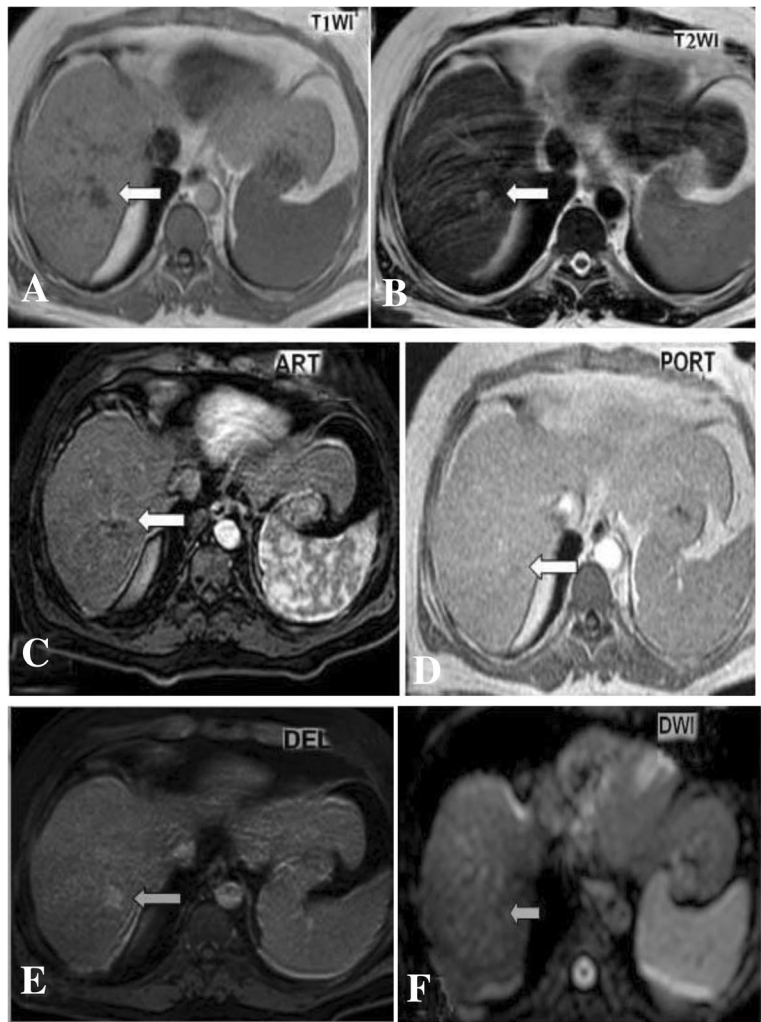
A 56-year-old male had cirrhotic liver and right hepatic lobe focal lesion with an atypical pattern of enhancement on triphasic CT study. a An axial unenhanced T1W image shows the right hepatic lobe segment VII focal lesion of hypointense signal (arrow). b An axial T2W image shows the lesion of hyperintense signal (arrow). c An axial post-contrast arterial phase image shows hypoenhancement of the lesion (arrow). d, e An axial and delayed image shows contrast uptake without washout or enhancing capsule (arrow). f DWI of the lesion had low signal intensity (non-restricted diffusion) (arrow) with ADC value of $1.5 \times 10^{-3} \text{ mm}^2/\text{s}$. Suggested MRI diagnosis: right hepatic lobe hemangioma
